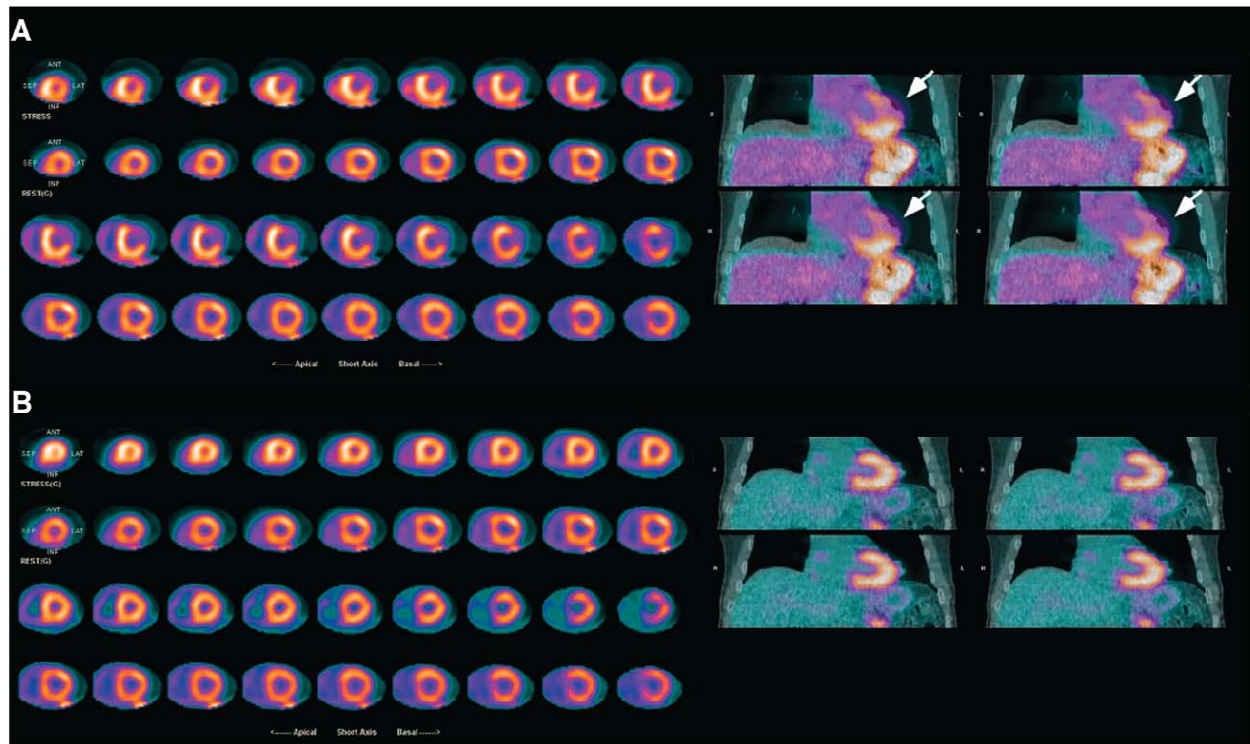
Transmission–emission misalignment. (A) Misaligned CT transmission and ^{82}Rb images (right) and resulting anterolateral perfusion defect on stress–rest ^{82}Rb PET (left). Perfusion defect results from applying incorrect attenuation coefficients during tomographic reconstruction to area of LV myocardium overlying lung field on CT transmission scan (arrows). (B) Correction of emission–transmission misalignment (right) and resulting normal perfusion study.
